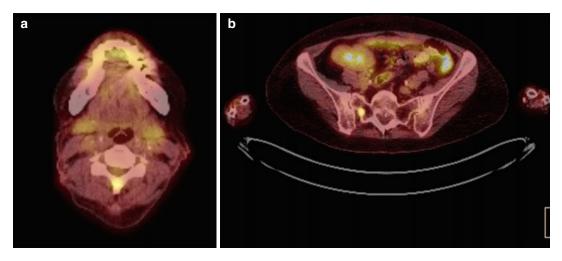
PET/CT scan (axial slices) at time of relapse of disease, 4 years after radiation therapy to the plasmacy-toma of the right scapula, showing multiple bone lesions
